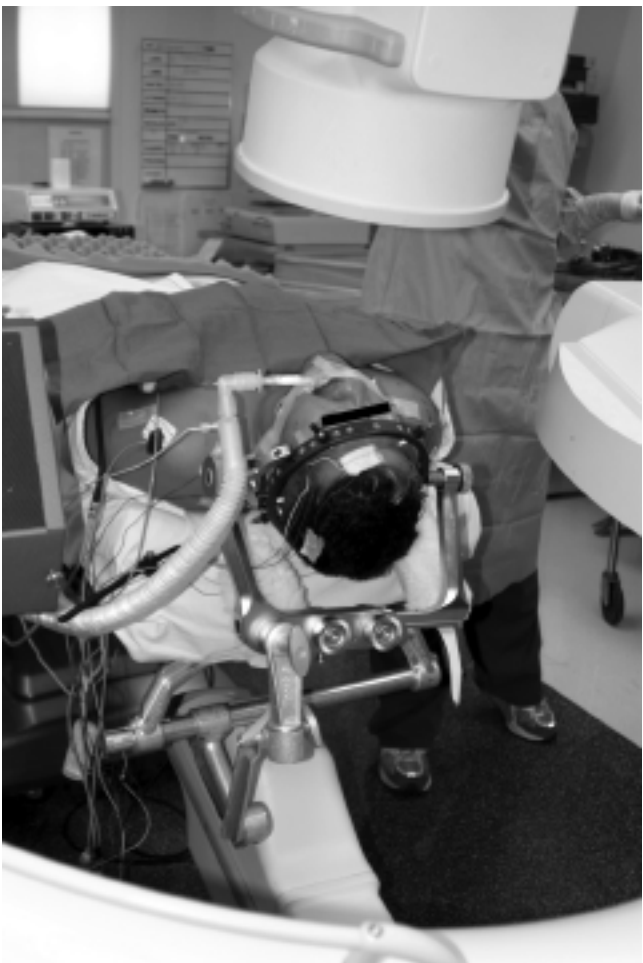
Photograph of a patient in an external halo orthosis who had an unstable Type II odontoid fracture. The headholder was fixed at three points in the rungs of the halo ring. The articulating arm was affixed in a paramedian port on the headholder. In this setup, the articulating arm is outside the field of view when an open-mouth x-ray film is obtained.
